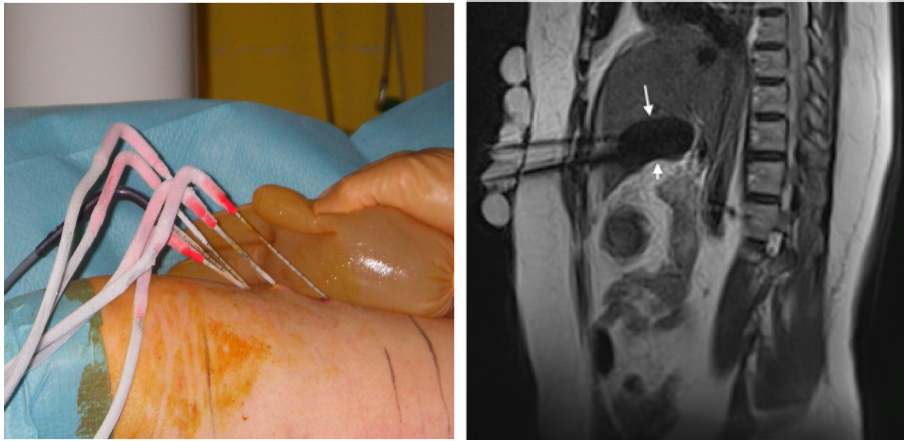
a)Cryoablation procedure with several probes to enlarge the lesion. The hot water in the glove protects the skin from the very low temperature of the cryoprobes. b)Typical MR image of a cryoablation showing the iceball (arrows). Courtesy of Department of Interventional Radiology of the Strasbourg University Hospital.
